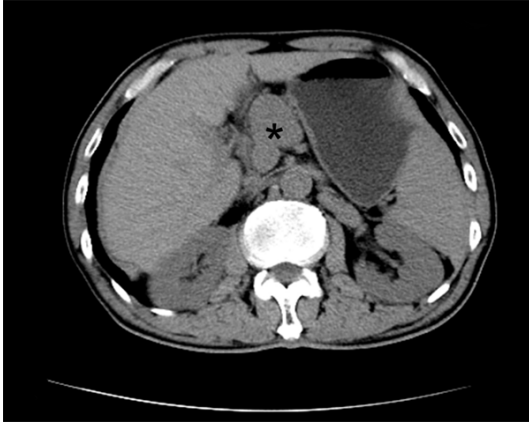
Case 2. The CT scan confirmed a heterogeneous mass between the liver, stomach and pancreas (*).
